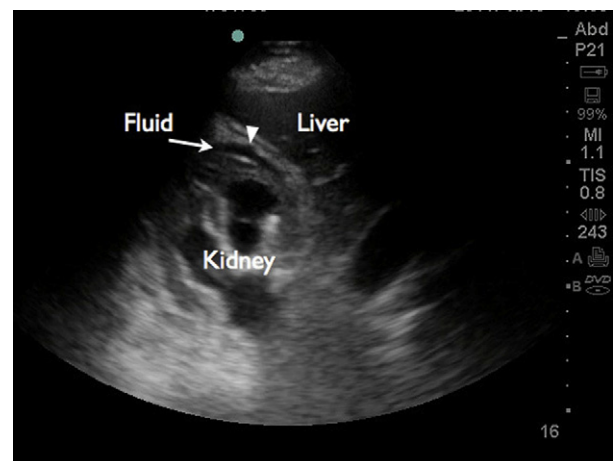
Transverse ultrasound image demonstrating free fluid between the liver and kidney; arrowhead demonstrating the hyperechoic line on the hepatic side of the fluid.
